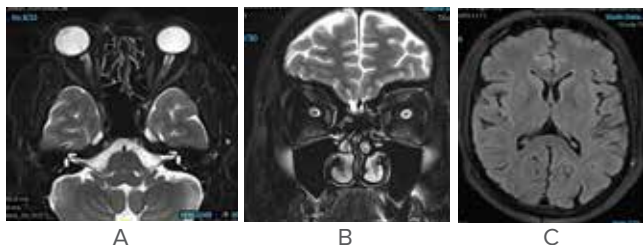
Magnetic resonance imaging (MRI) brain and orbit images.
